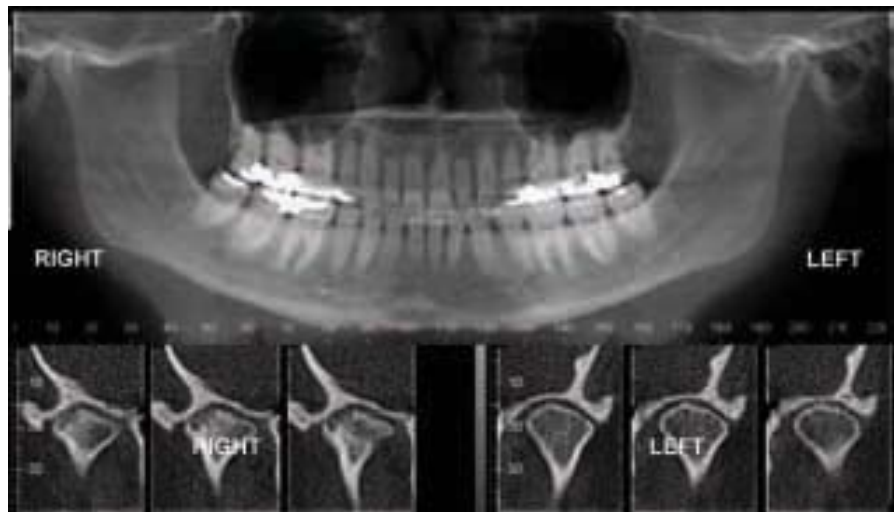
CBCT applications in TMJ assessment. Reformatted 'panoramic' image (top) showing right side condyle differences in shape compared to normal left. Cropped para-coronal reformatted images clearly showing subcortical cystic defects in surface of right condyle as compared to the left indicative of active degenerative joint disease. (Volumetric data set acquired with iCAT).
